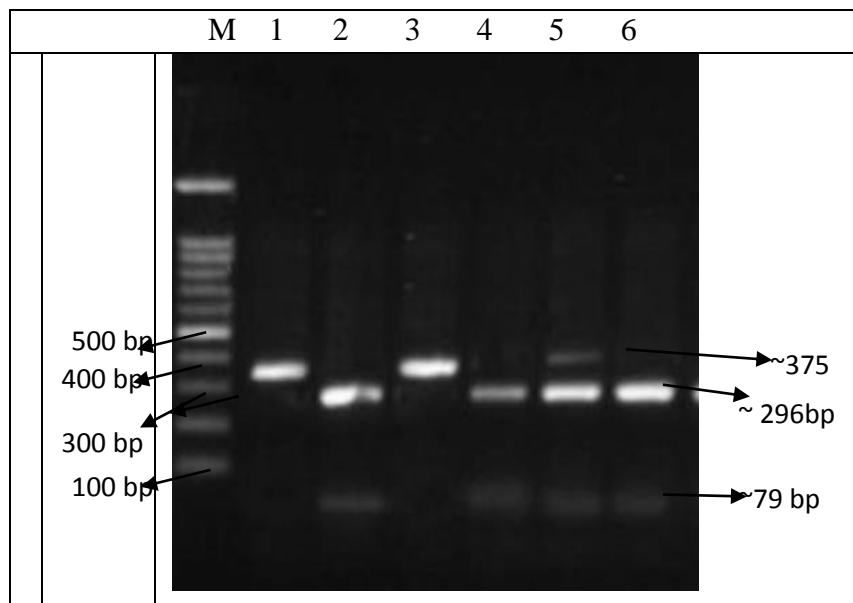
Agarose gel Image of CYP2C9*2: Lane M, 500-bp ladder; Lanes 1 and 3 were TT mutant homozygous with fragment of 375 bp, Lanes 2, 4, were CC wild homozygous with fragment of 296-bp,79-bp. Lanes 5 CT heterozygous with fragments of 375 bp,296 bp,79 bp
